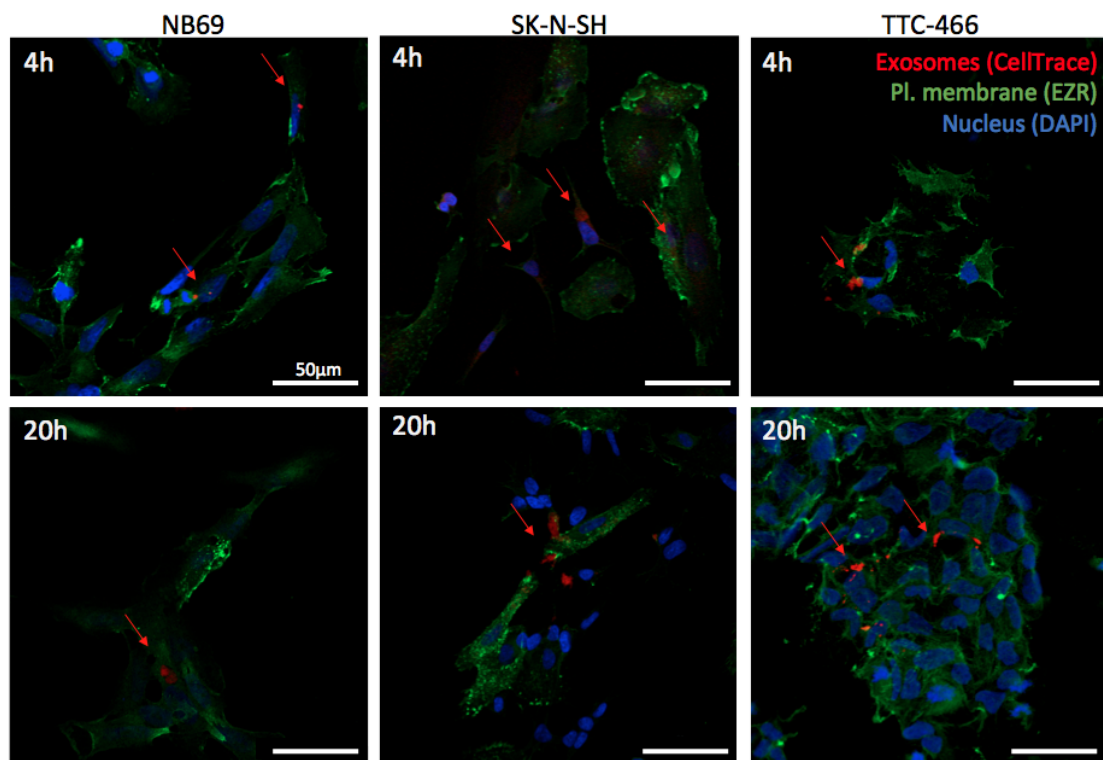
Evaluation of SK-N-MC exosome uptake by NB69, SK-N-SH and TTC-466 cell lines evaluated by IF. SK-N-MC exosomes (CellTrace, red arrows) taken up by (left to right) NB69 NBL cells, SK-N-SH NBL cells and TTC-466 ES cells at 4 h and 20 h. Red = CT (exosomes); Green = Plasma membrane (anti-EZR); blue = DAPI (nucleus).
